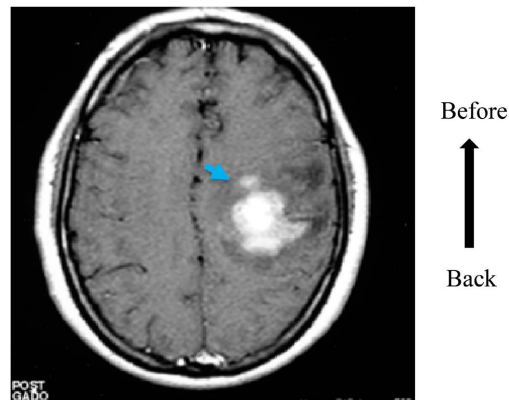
Brain metastases (Arrows) at the house of a 55-year-old patient with colorectal cancer. T1-weighted MRI axial slice showing 2 brain lesions in the left frontal lobe (→) and the other in the right occipital lobe with surrounding perilesional edema (→). Enhancement of the lesions in an annular and heterogeneous manner.
